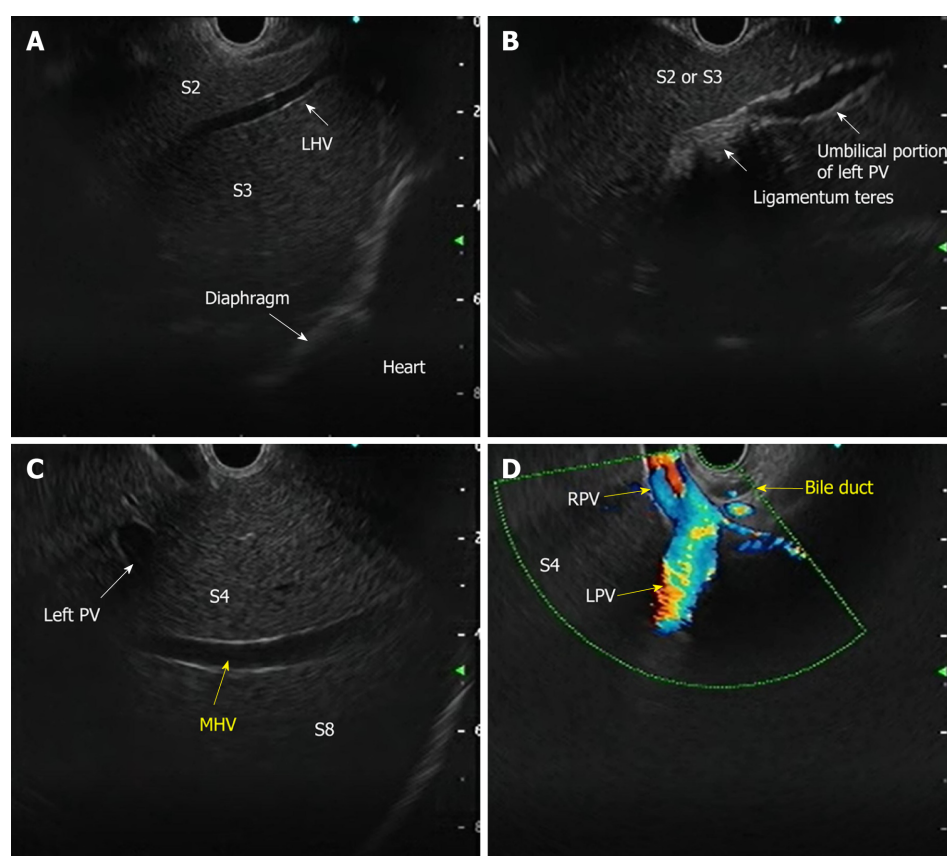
Endoscopic ultrasound anatomy of liver segments. A: Anatomy of the left lobe with S2 and S3 segments; B: Ligamentum teres with umbilical portion of the left portal vein; C: Middle hepatic vein with segments of the liver; D: Anatomy of the bifurcation of portal vein from the duodenal bulb. PV: Portal vein; MHV: Middle hepatic vein; LHV: Left hepatic vein; RPV: Right portal vein; LPV: Left portal vein.
